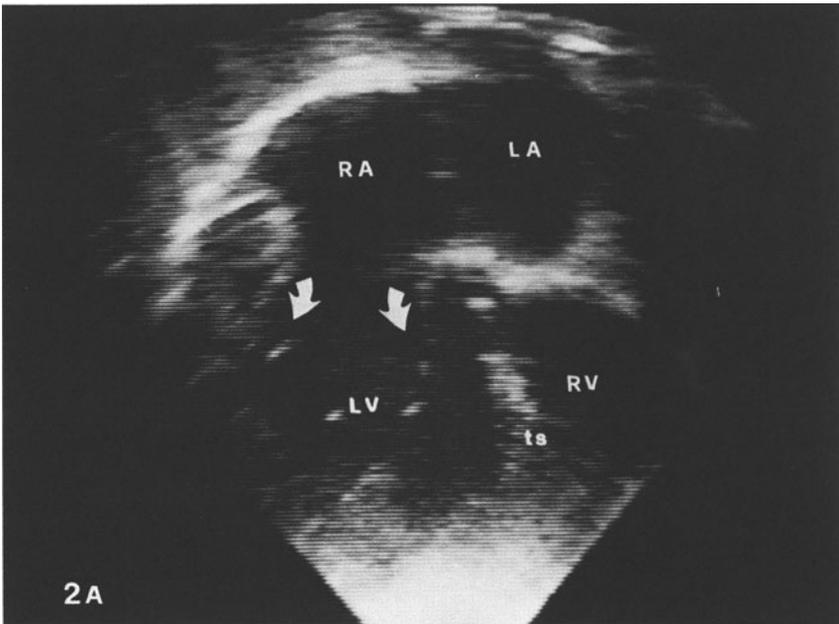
Apical four-chamber cuts (with two different transducer angulations) in a patient having double-inlet left ventricle and two AV valves with crossing of tension apparatus (abbreviations are the same as in Figure 1).
